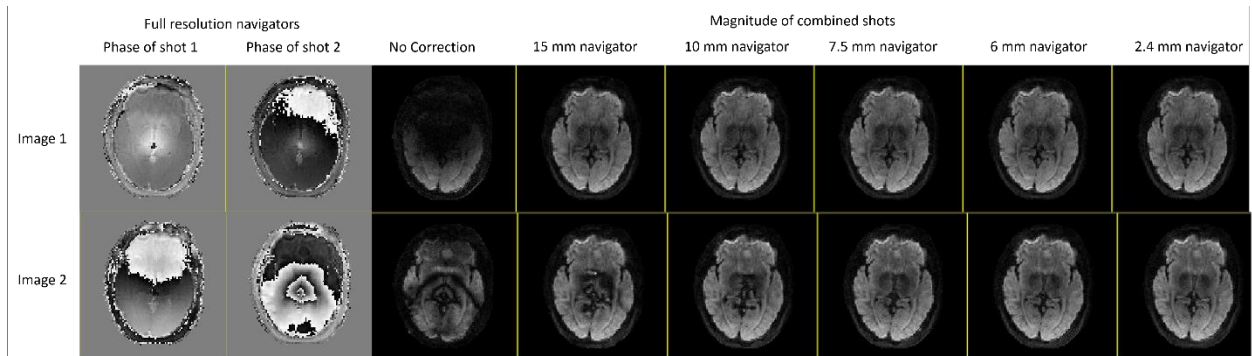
DWI reconstructed with navigators of different spatial resolutions.
